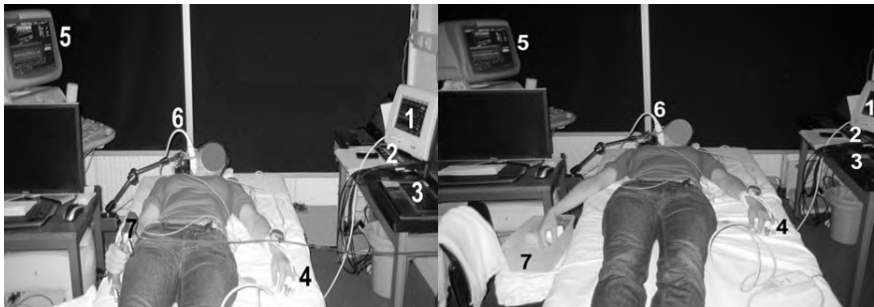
General protocol setup. (1) Nexfin monitor (Nexfin, BMEYE B.V., Amsterdam, The Netherlands), (2) National instruments acquisition device (SC-2345, National instruments, Austin (Texas), United States), (3) External PC, (4) Finger cuff, (5) Ultrasound device (Vivid7, GE-Vingmed Ultrasound AS, Horten, Norway), (6) Ultrasound probe. Left) HGT: (7) Hand grip device (Precision dynamometer G200, Biometrics Ltd, Newport, United Kingdom). Right) CPT: (7) Cold water. Figure adapted from [5].
